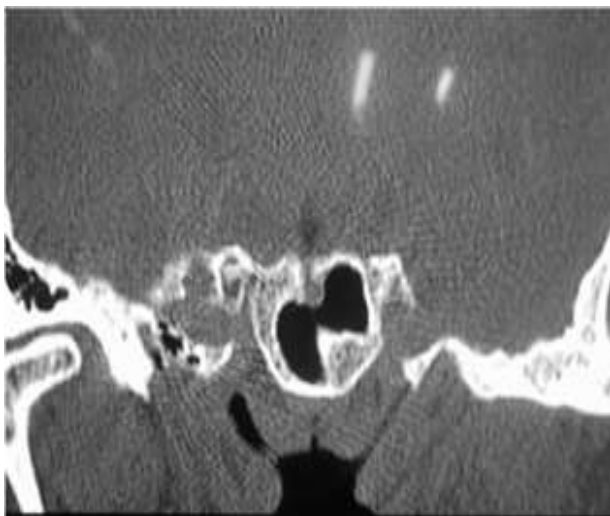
CT Scan (Patient 2) showing a defect in the clivus with a protruding meningocele.
